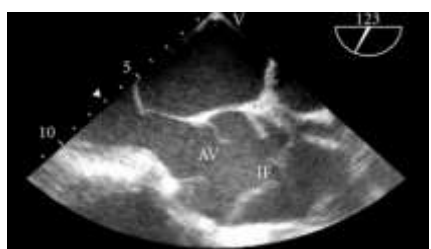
showing aortic ring dilation and dissection by Trans esophageal echocardiography(TEE)
